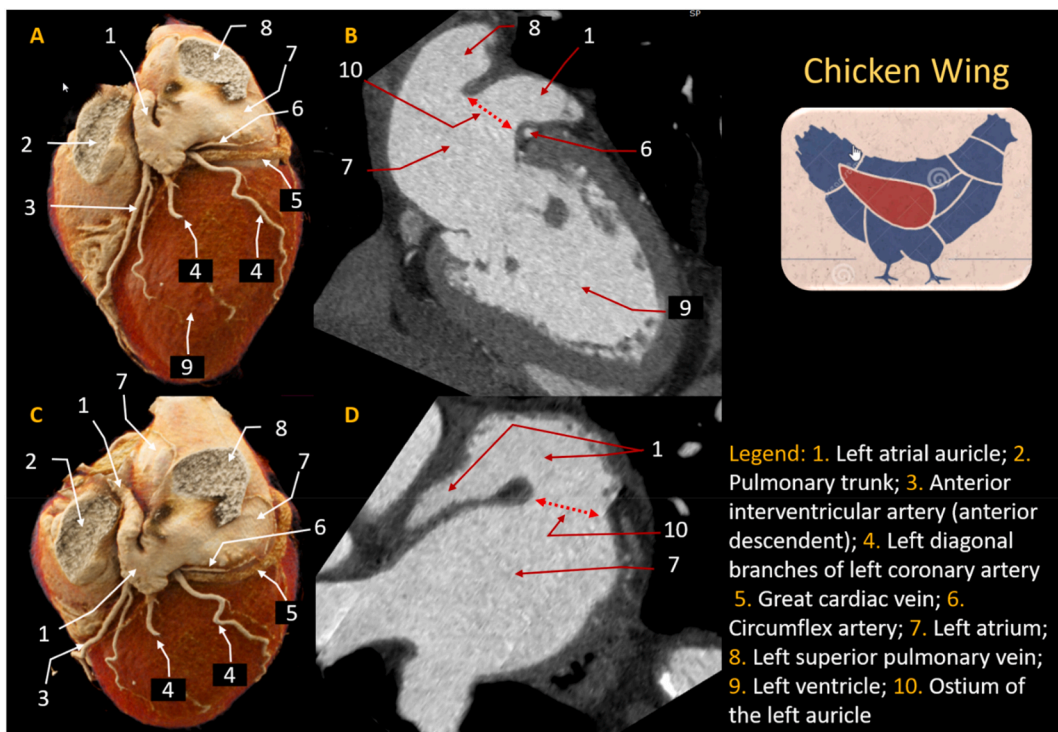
(A–D). Cinematic rendering (A,C) and multiplanar (B,D) CT reconstruction images of “chicken wing” LAA morphology.
